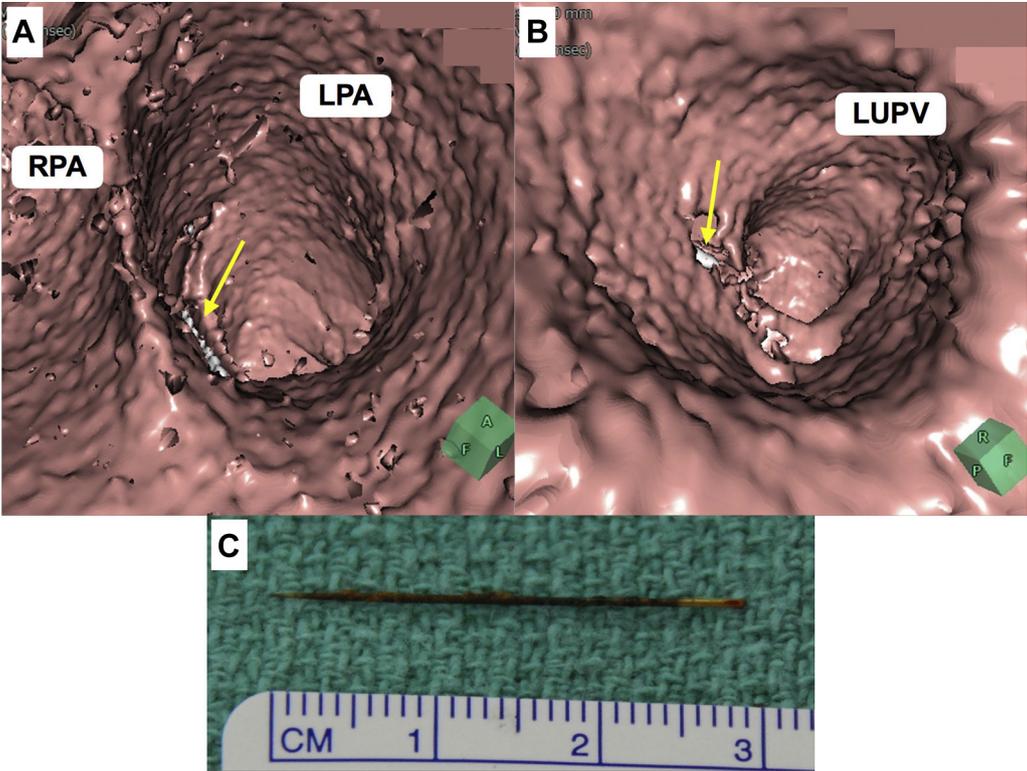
Volume-rendering endoscopic images of 3-dimensional computed tomography showing a needle (arrow) on the surface of (A) the left pulmonary artery (LPA) and (B) the left upper pulmonary vein (LUPV). (C) The rusted sewing needle after extraction. RPA, right pulmonary artery.
